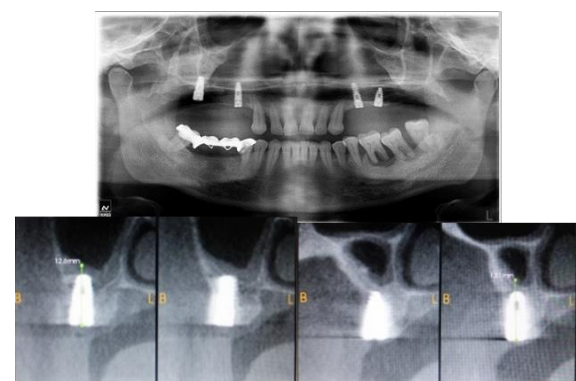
Post-op OPG and CT Scan (Direct Sinus Lift).
